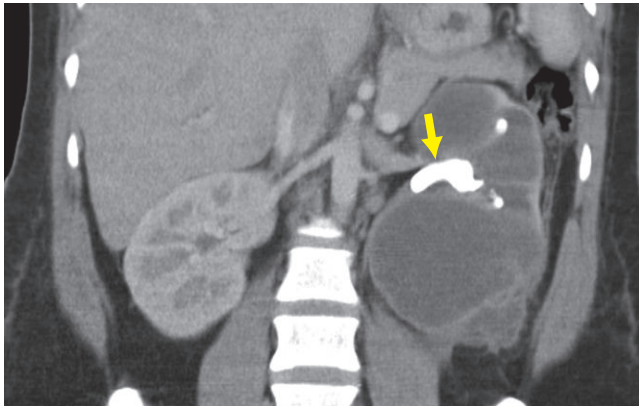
Correlative CT scan demonstrates the very thin renal cortex with replaced renal parenchyma. Note: Central staghorn calculi (arrow). Also note the more focal bulge of the left lower pole.
